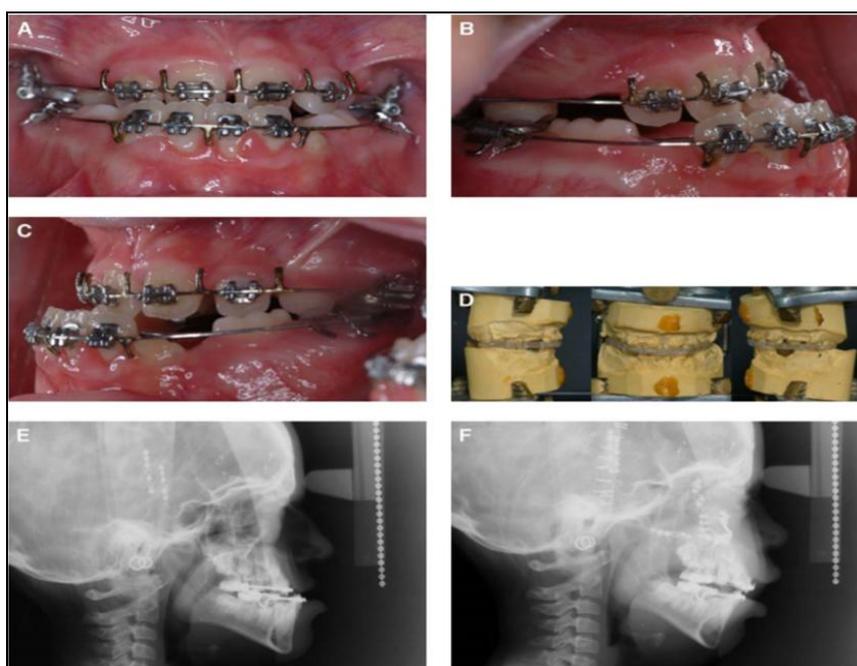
The same patient seen after initial phase of orthodontic treatment. (A, B, C) Patient with Crouzon syndrome after preparation for early midface advancement, with fixed orthodontic appliances, full size wires, and surgical lugs in place. (D) The surgical models show the acrylic splint for surgery fabricated in the desired advancement position. (E and F) Cephalometric radiographs before and after monobloc midface advancement. (Photographs courtesy of Dr. Ramon L. Ruiz, DMD, MD, Chapel Hill, NC [27])
